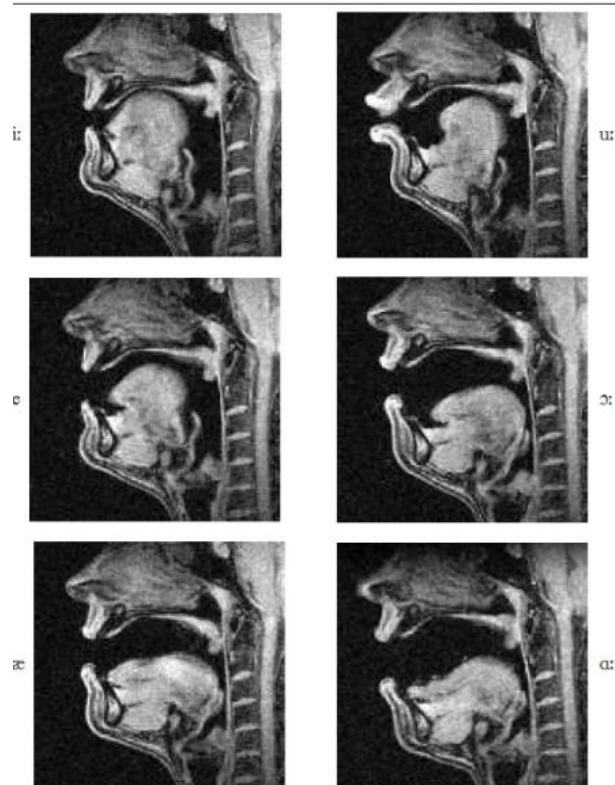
MRI images of the position of the organs concerned at the time of vocal emission.
